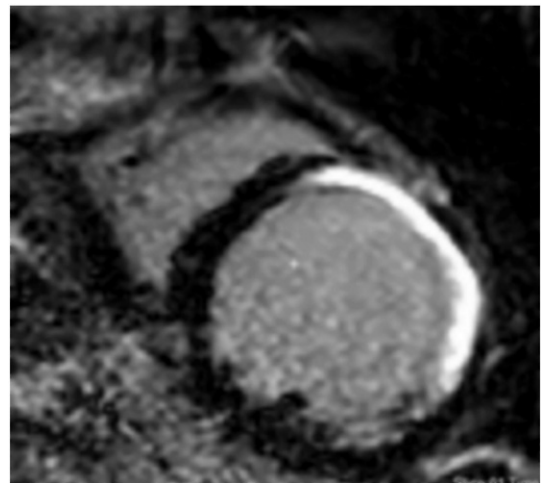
LGE in myocardial infarction. A LGE image of a 73-year-old patient initially suspected of having a left ventricular aneurism. MR imaging demonstrates a perfusion defect on dynamic post gadolinium images (not shown), akinesis on cine images (not shown), and intermediate/high-intensity LGE involving the anterior wall, findings consistent with a transmural myocardial infarction.
